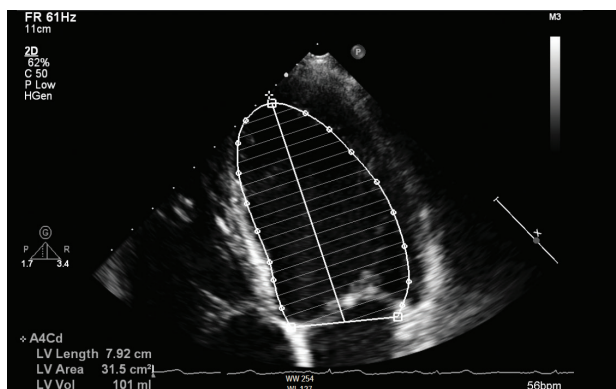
Post-treatment echocardiogram shows a normal left ventricle with an improved end-diastolic volume at 101 mls.
